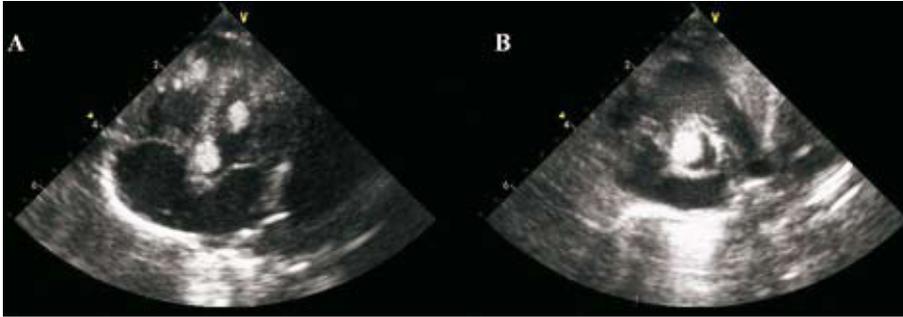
Two-dimensional echocardiography images in apical 4-chamber view (A) and short axis at the level of the left ventricular outflow tract (B) in which we observe the presence of multiple tumorous masses, with a higher echogenicity than that of the adjacent myocardium, compatible with multiple cardiac rhabdomyoma.
